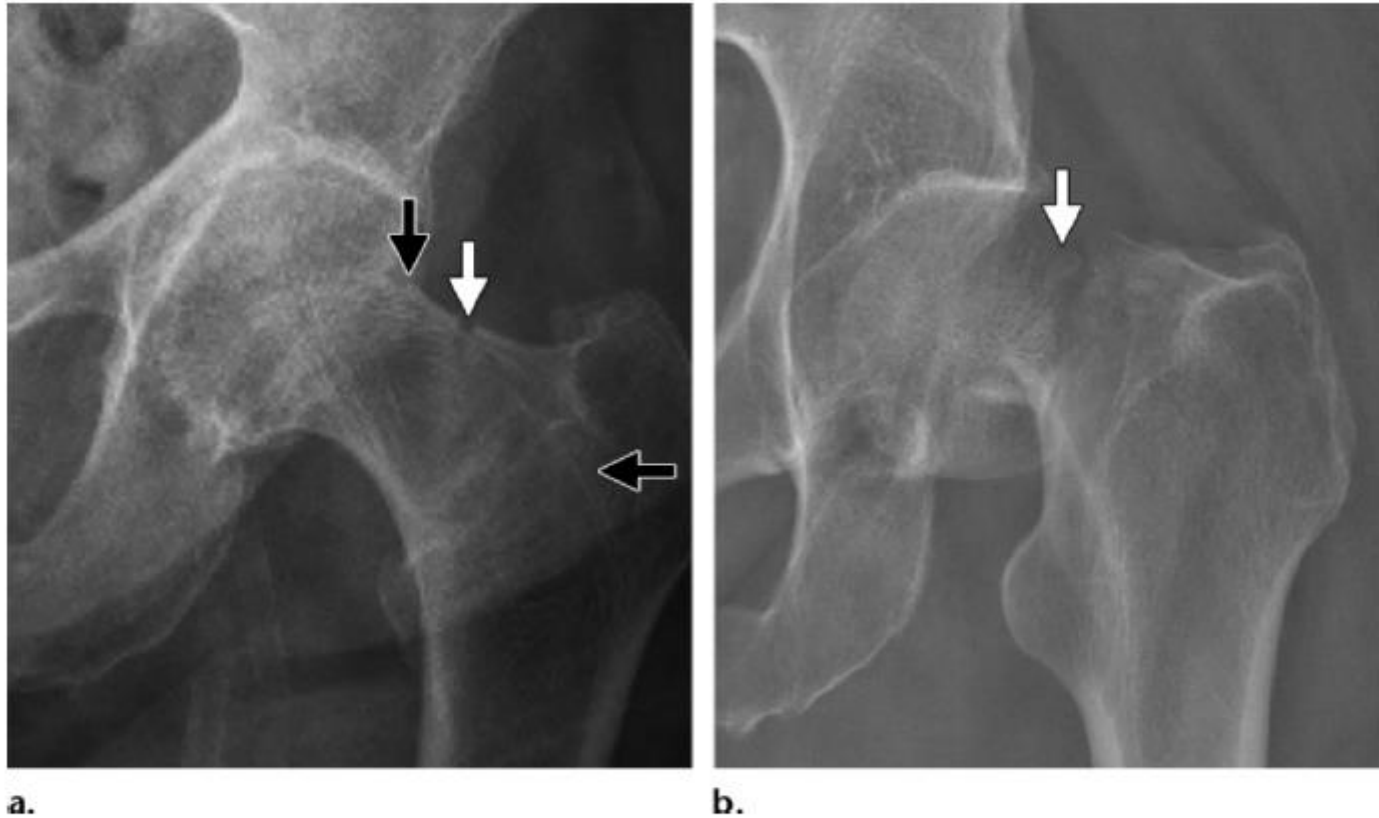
Sequential images of the left hip in an 85-year-old woman with osteoporosis and complaints of groin pain. (a) Initial anteroposterior radiograph demonstrates focal disruption of the lateral femoral cortex (white arrow) with the fracture line oriented perpendicular to the primary tensile trabeculae (black arrows). The patient was diagnosed with an incomplete insufficiency-type stress fracture and was placed under strict activity restrictions. (b) Follow-up anteroposterior radiograph obtained after acute atraumatic exacerbation of groin pain demonstrates completion of the now-displaced femoral neck fracture (arrow).
